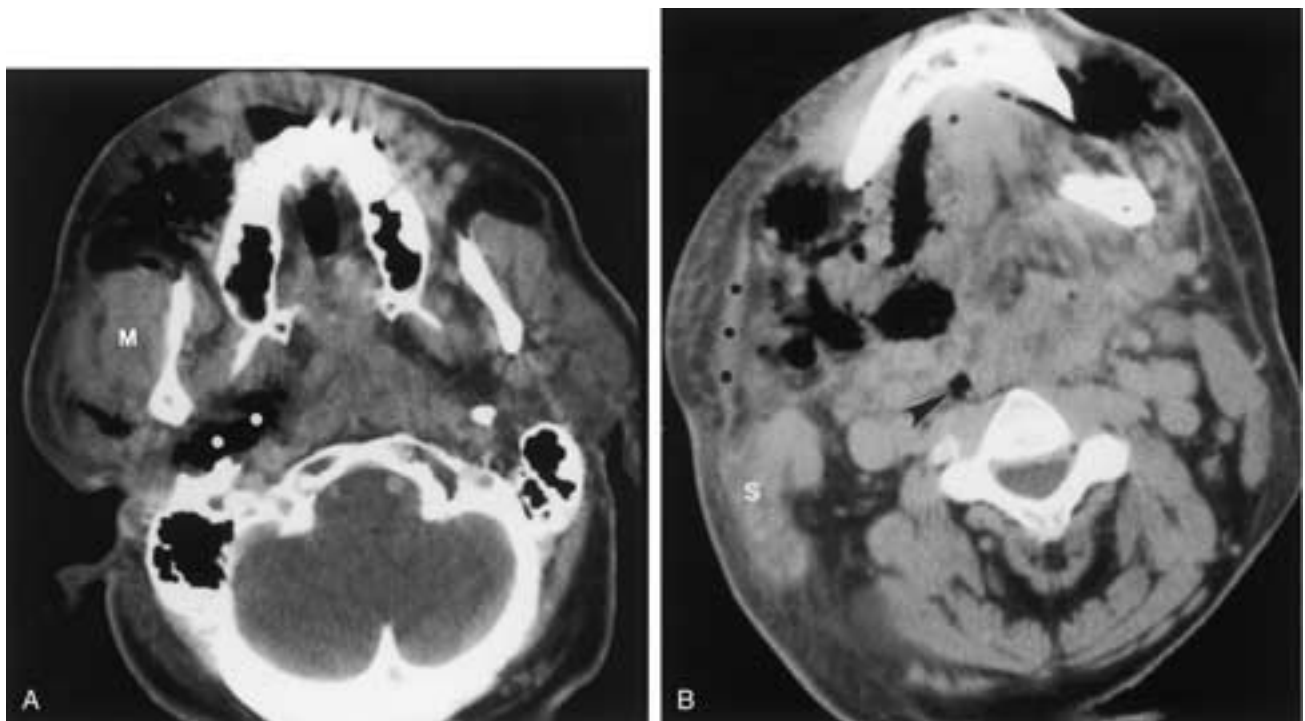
Gas-forming infection. A, Axial contrast-enhanced CT scan at the level of the maxilla reveals extensive infection with gas collections involving multiple spaces of the suprahyoid neck. These include the buccal spaces bilaterally and the right parapharyngeal space (*white dots*). Myositis involving the right masseter muscle (*M*) is easily appreciated. Involvement of the subcutaneous fat on the right is also identified at this level. B, Axial CT scan at a lower level demonstrates gas collections within the right sublingual space, the submandibular spaces bilaterally, the right parapharyngeal space, and the right retropharyngeal space (*arrowhead*). Note the myositis involving the right sternocleidomastoid (*S*) and platysma (*black dots*) muscles. Extensive subcutaneous infection is manifested by edema and a “dirty” appearance of the fat. Although this is most prominent on the right, it is also identified anteriorly on the left. Note the absence of a patent airway at this level.
